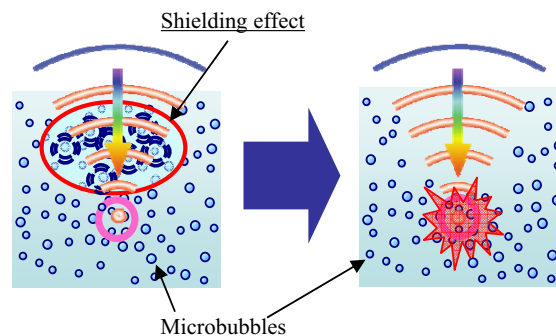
Idea to heat up the only focus. This method is that the very short burst wave destroys the microbubbles in front of focus that disturb the ultrasound propagation and make a path of ultrasound for heating.
